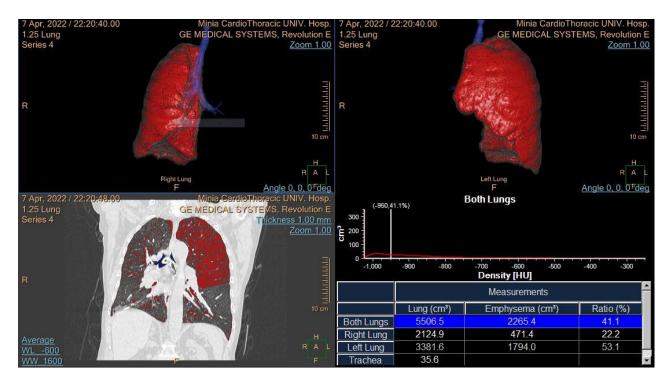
the case is for male patient 50 years old, current smoker, volumetric CT shows emphysematous changes on both lung fields about 41%, it affects more the left upper lung lobe.
